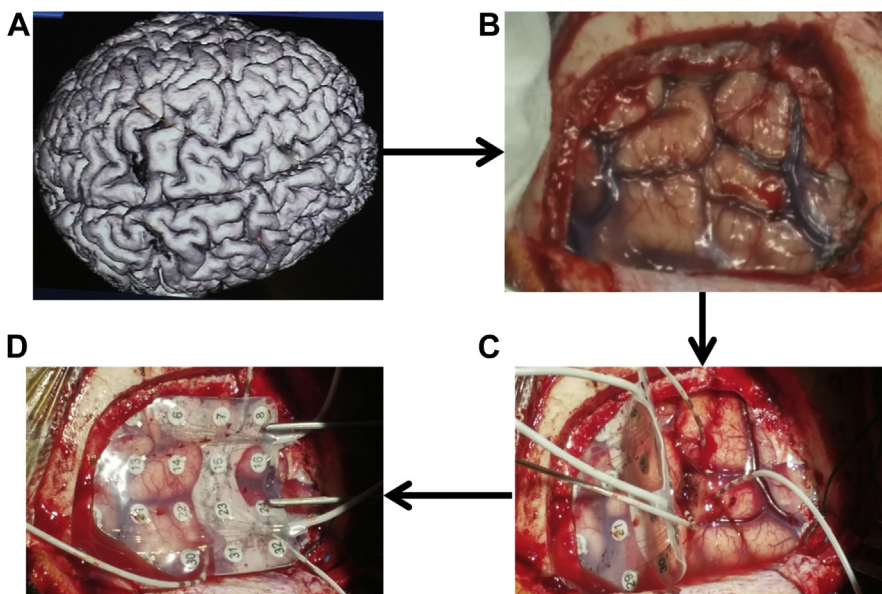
Preparation and location of intracranial electrodes for functional mapping in telemetry in a 16-year-old patient. (A) Three-dimensional brain MRI showing a lesional region over the posterior aspect of the left frontal lobe. (B) Opening of the bone and dura. (C) Initial positioning of a combination of depth electrodes and a subdural mat to cover the supplementary and primary motor cortex. (D) Final position of electrodes.
